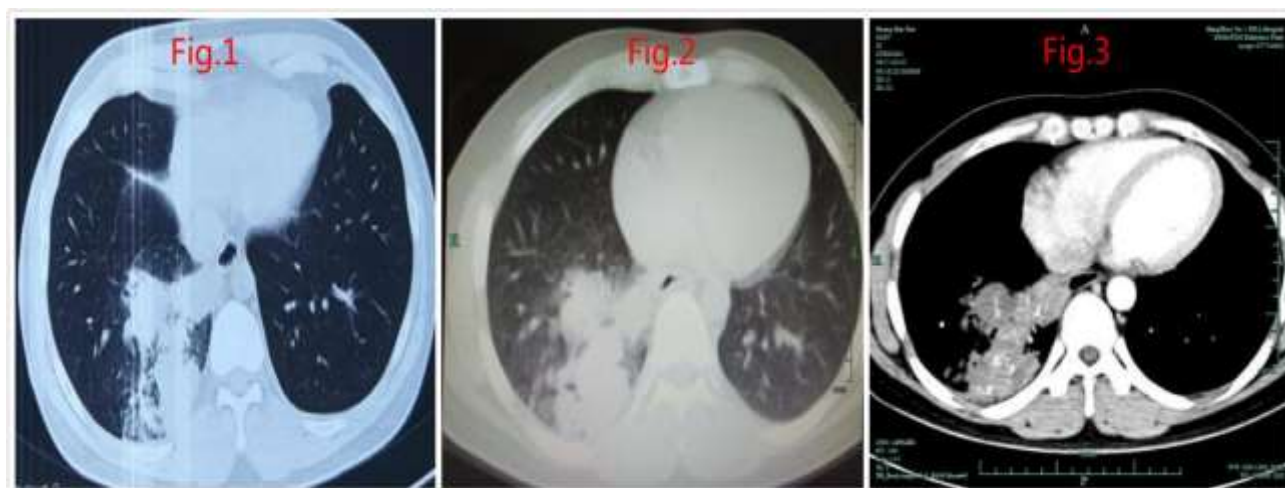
First chest CT half a month ago; Figure 2-3. Second chest CT after half a month
